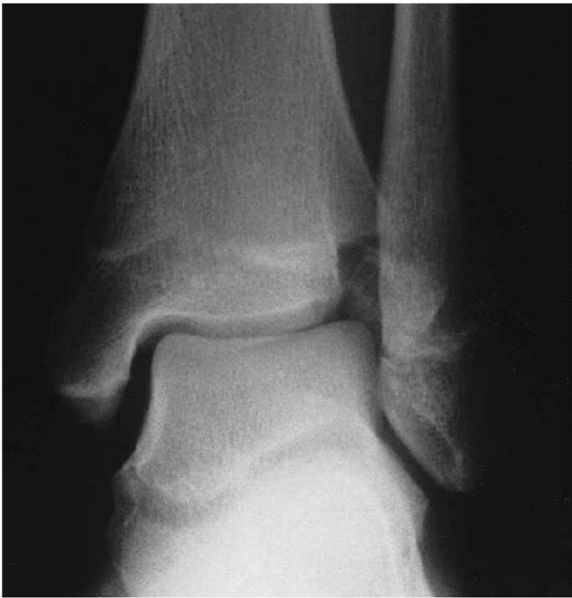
Pre-operative AP X-ray ankle joint view showing displaced Tillaux fracture.
